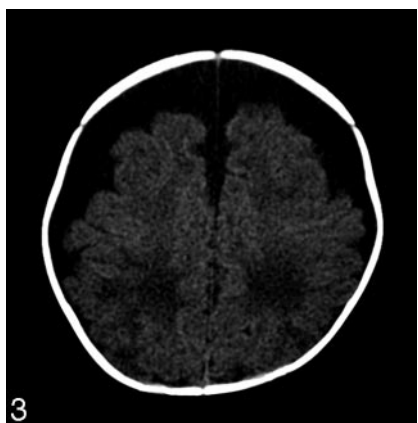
Axial CT scan showing prominent subarachnoid spaces in both frontal regions.
